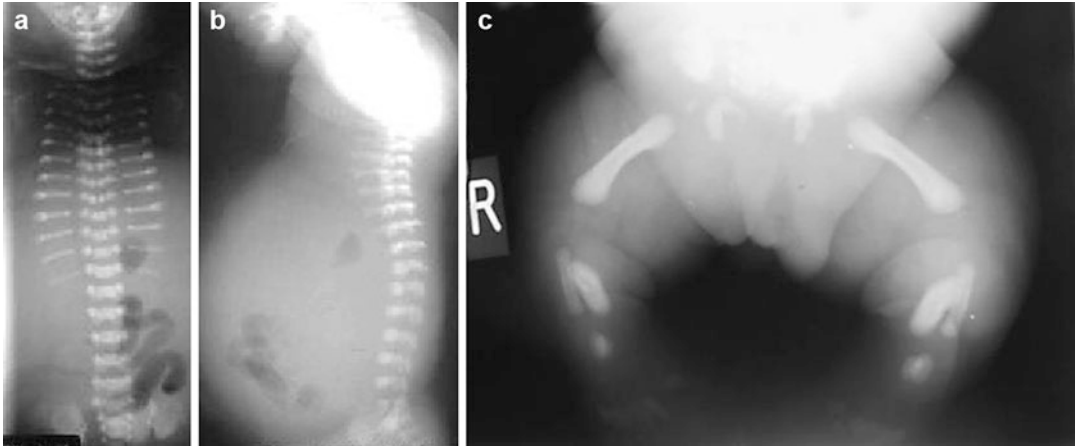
(a–c) Radiographs (SRPS II) showing extremely short and horizontal ribs, high clavicles, unremarkable spine and pelvis, and premature ossification of the proximal epiphyses of the humeri, femora, and lateral cuboids.
